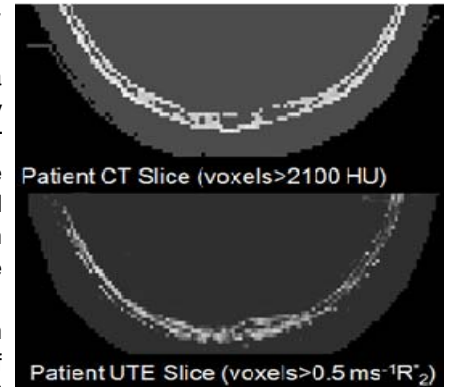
The same slice on the CT and UTE images is shown depicting similar bone contours.
